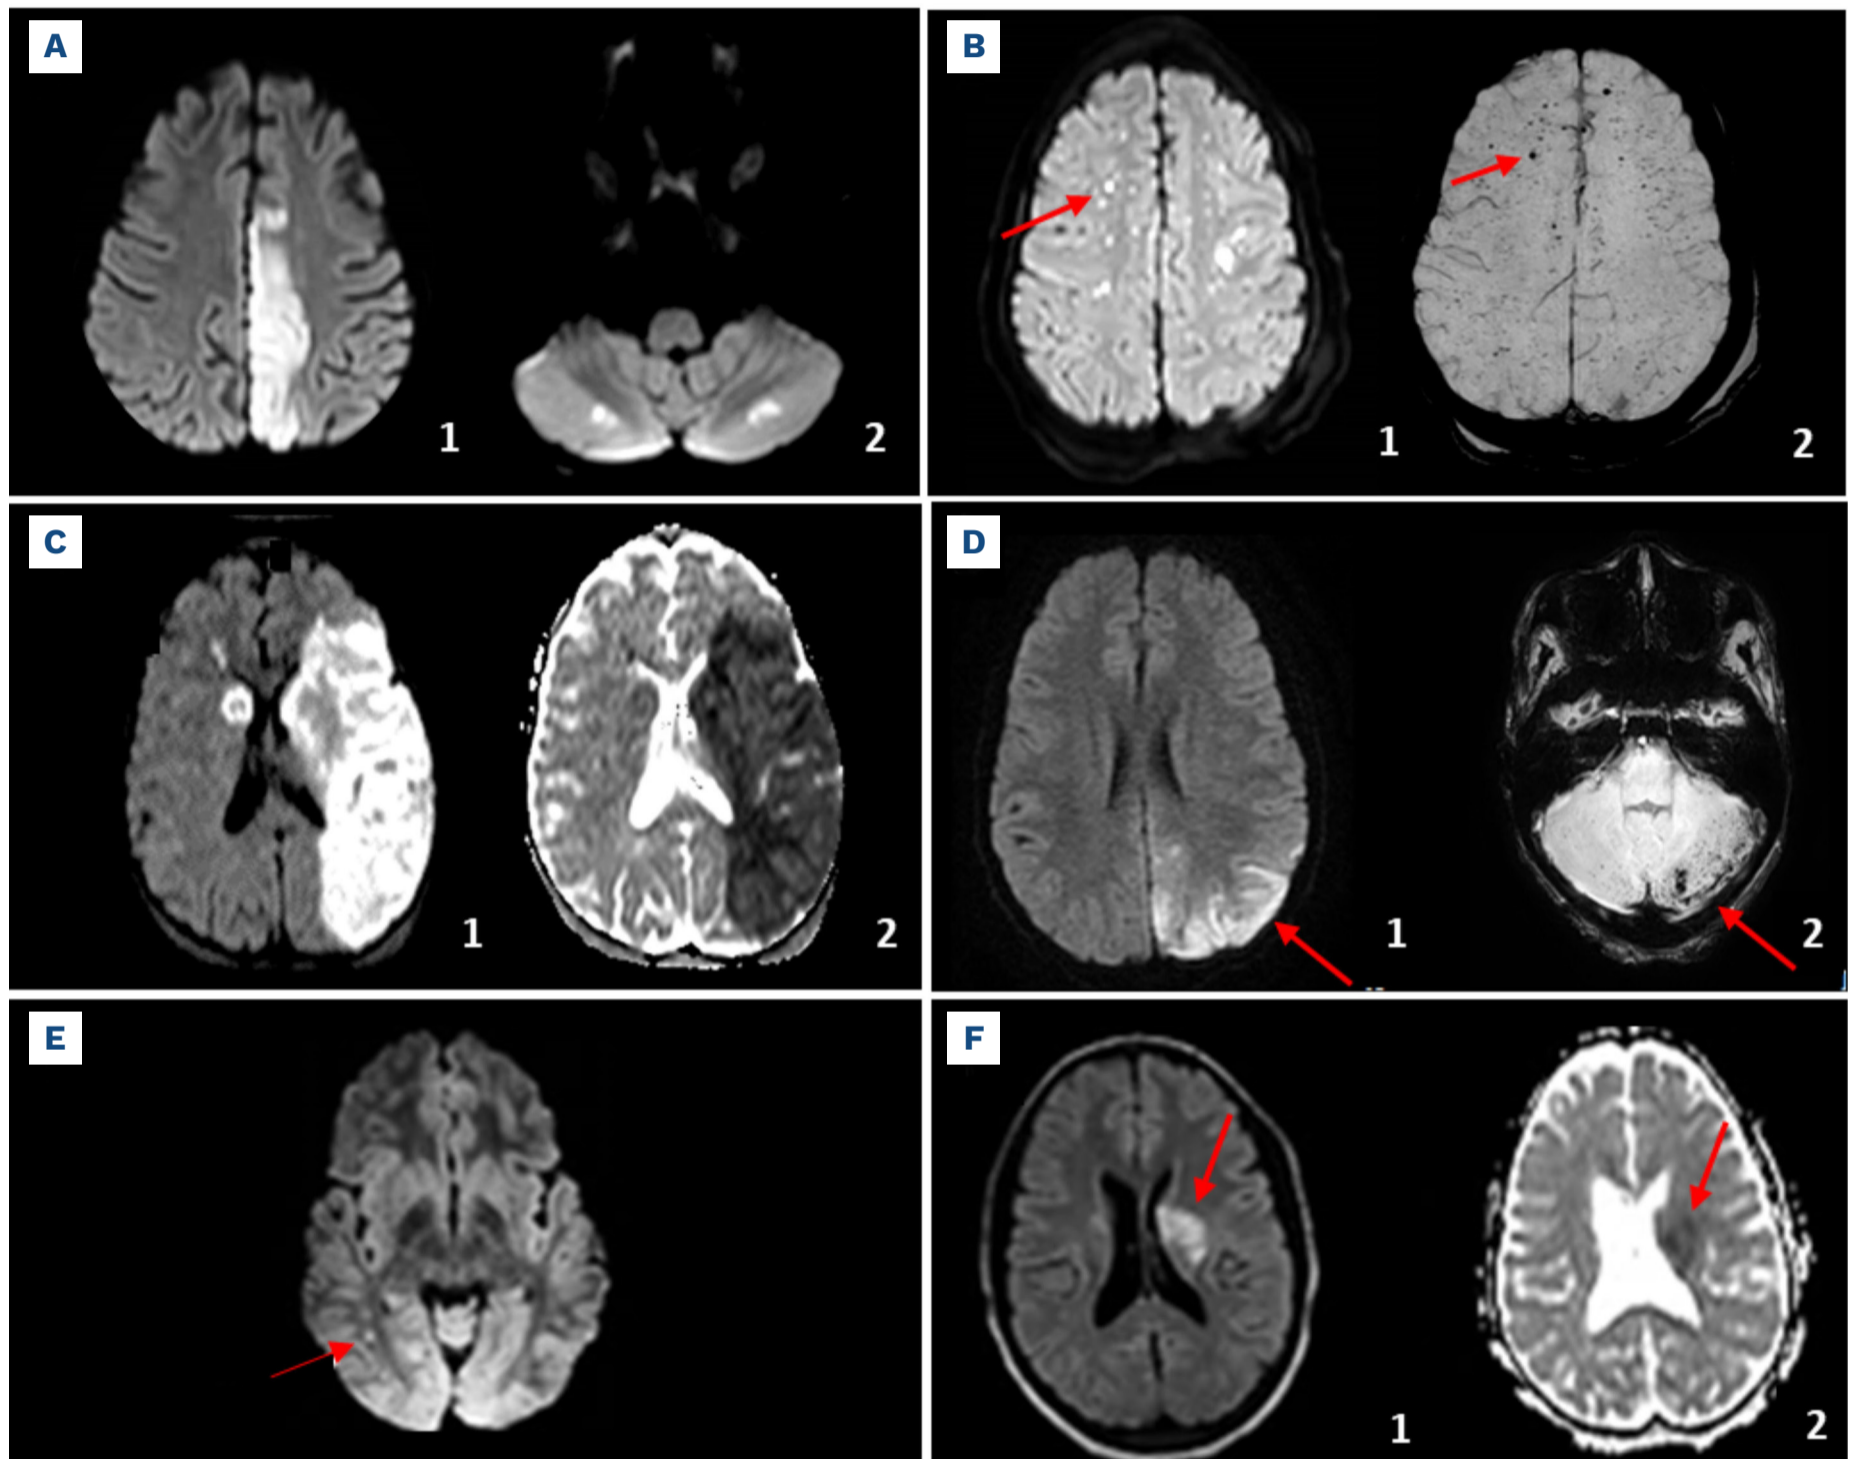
Representative brain magnetic resonance images of ischemic stroke of various etiologies in children with sickle cell disease with no sickle-related cerebral arteriopathy. (A) Reversible cerebral vasoconstriction syndrome (patient 1). (A1) Axial supratentorial view in diffusion weighted imaging (DWI) sequence showing a left medial parietal-occipital lesion. (A2) Axial infratentorial DWI view showing focal lesions in both cerebellar lobes. (B) Cerebral fat embolism syndrome (patient 10). (B1) Axial DWI view. (B2) Axial susceptibility weighted imaging (SWI) sequence: bilateral multiple punctiform ischemic and hemorrhagic lesions in the subcortical region and deep white matter (red arrows). (C) Arterial thrombosis (patient 3). (C1) Axial DWI view. (C2) Axial view of apparent diffusion coefficient map (ADC). Acute ischemic lesions in the complete territory of the left middle cerebral artery and in the head of the right caudate nucleus and right frontal deep white matter. (D) Cerebral vasculitis complicating pneumococcal meningoencephalitis (patient 11)- (D1) Axial DWI view. Ischemic lesion in the left posterior cerebral artery territory (red arrow). (D2) Axial SWI, infratentorial view showing numerous petechiae predominating in the left cerebellar lobe (red arrow). (E) Low cerebral blood flow (patient 12). Axial DWI view: small foci of DWI hyperintensity in the right parietal-occipital white matter (red arrow). (F) Hyperviscosity (patient 8). (F1) Axial fluid attenuated inversion recovery (FLAIR) view. (F2) Axial ADC view. Ischemia in the left deep middle cerebral artery territory (red arrows).
